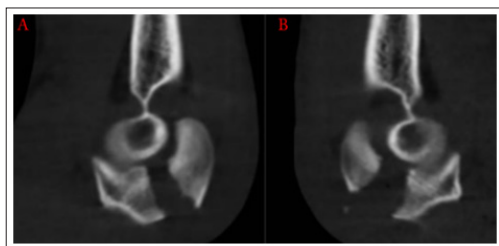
A: Computed Tomography (CT) Scans with Sagittal cut for the Left Elbow, B: Computed Tomography (CT) Scans with Sagittal cut for the Right Elbow, both Showing Trans olecranon Fracture.
